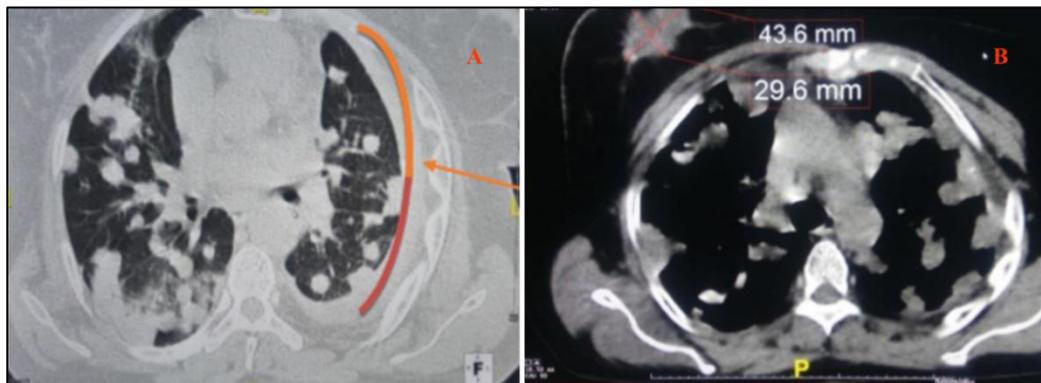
(A and B): Thoracic CT in axial section and parenchymal window (A): after injection of contrast product, bilateral parenchymal and subpleural nodules in balloon releases and pleurisy are evident. Thoracic CT in axial section and mediastinal window (B): after injection of contrast product, balloon releases show a right breast mass
